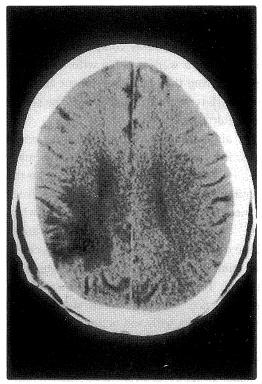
CT show the localized spacious right hemisphere lesion.
